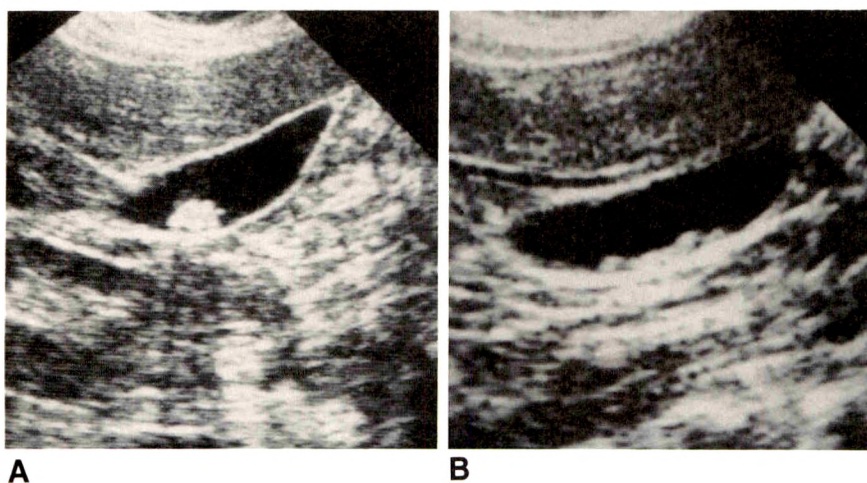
Sonographic misrepresentation of stone number.
